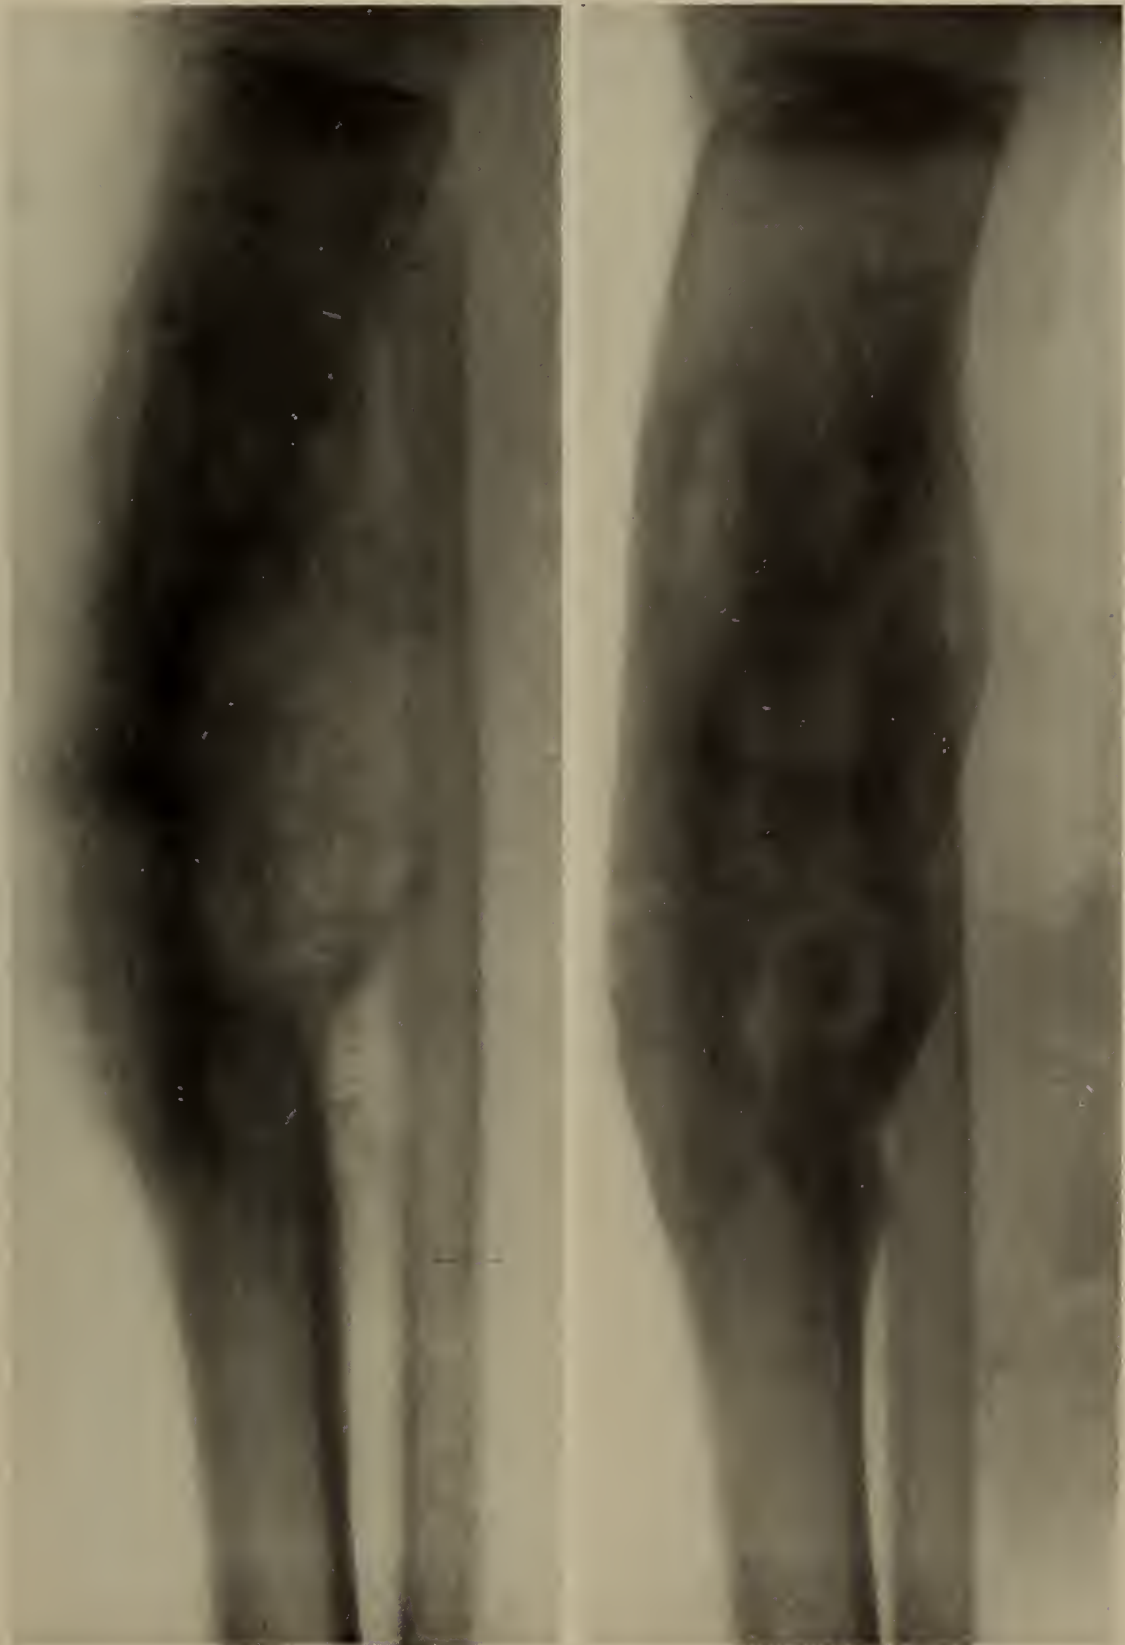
Case 538. The same case as that in Figure 65. Ewing's sarcoma. Showing the response to radiation therapy. Roentgenograms taken 16 months after the onset, (left) and after several exposures to roentgen rays. By a trial of radiation at a much earlier date one would have avoided in this case repeated exploratory operations.
